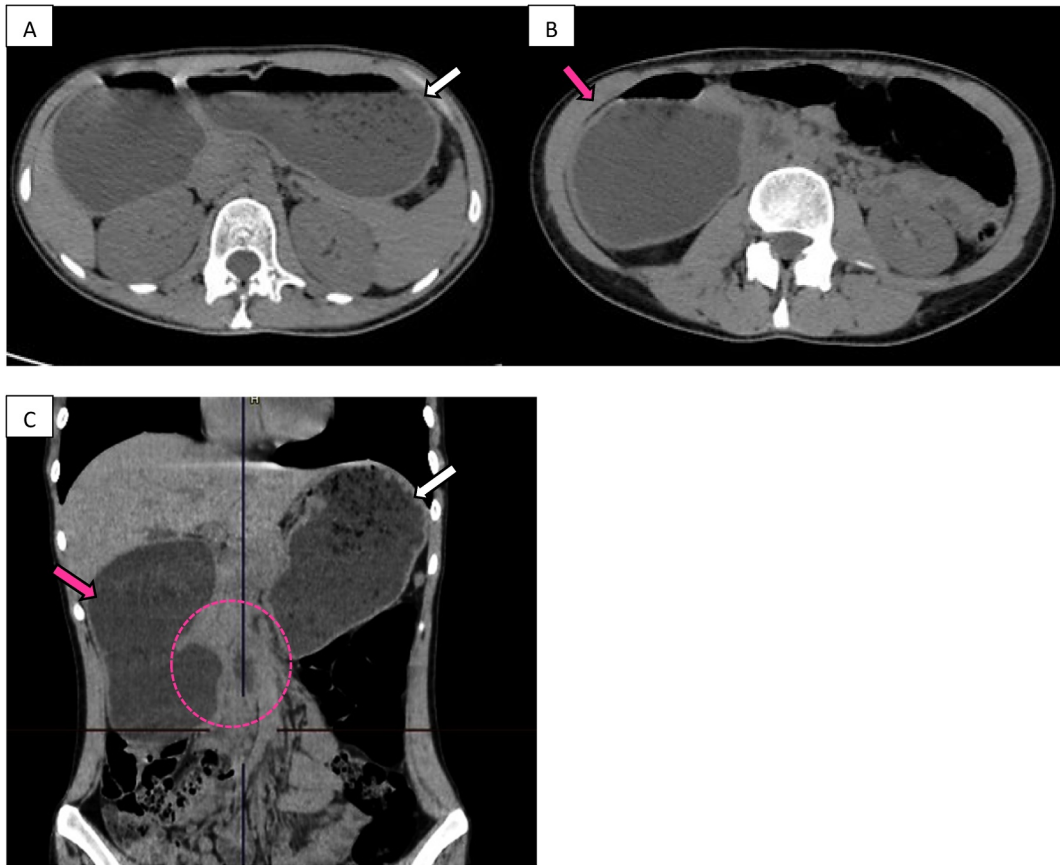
Cross-sectional computed tomography (CT) images (A and B) show significant gastric distention (A, white arrow) and marked dilation of the duodenal bulb (B, pink arrow). These findings are also evident on the coronal CT image, which shows a broad-based mass-like lesion without evidence of inflammation or wall infiltration in the second portion of the duodenum (C, dashed line).
